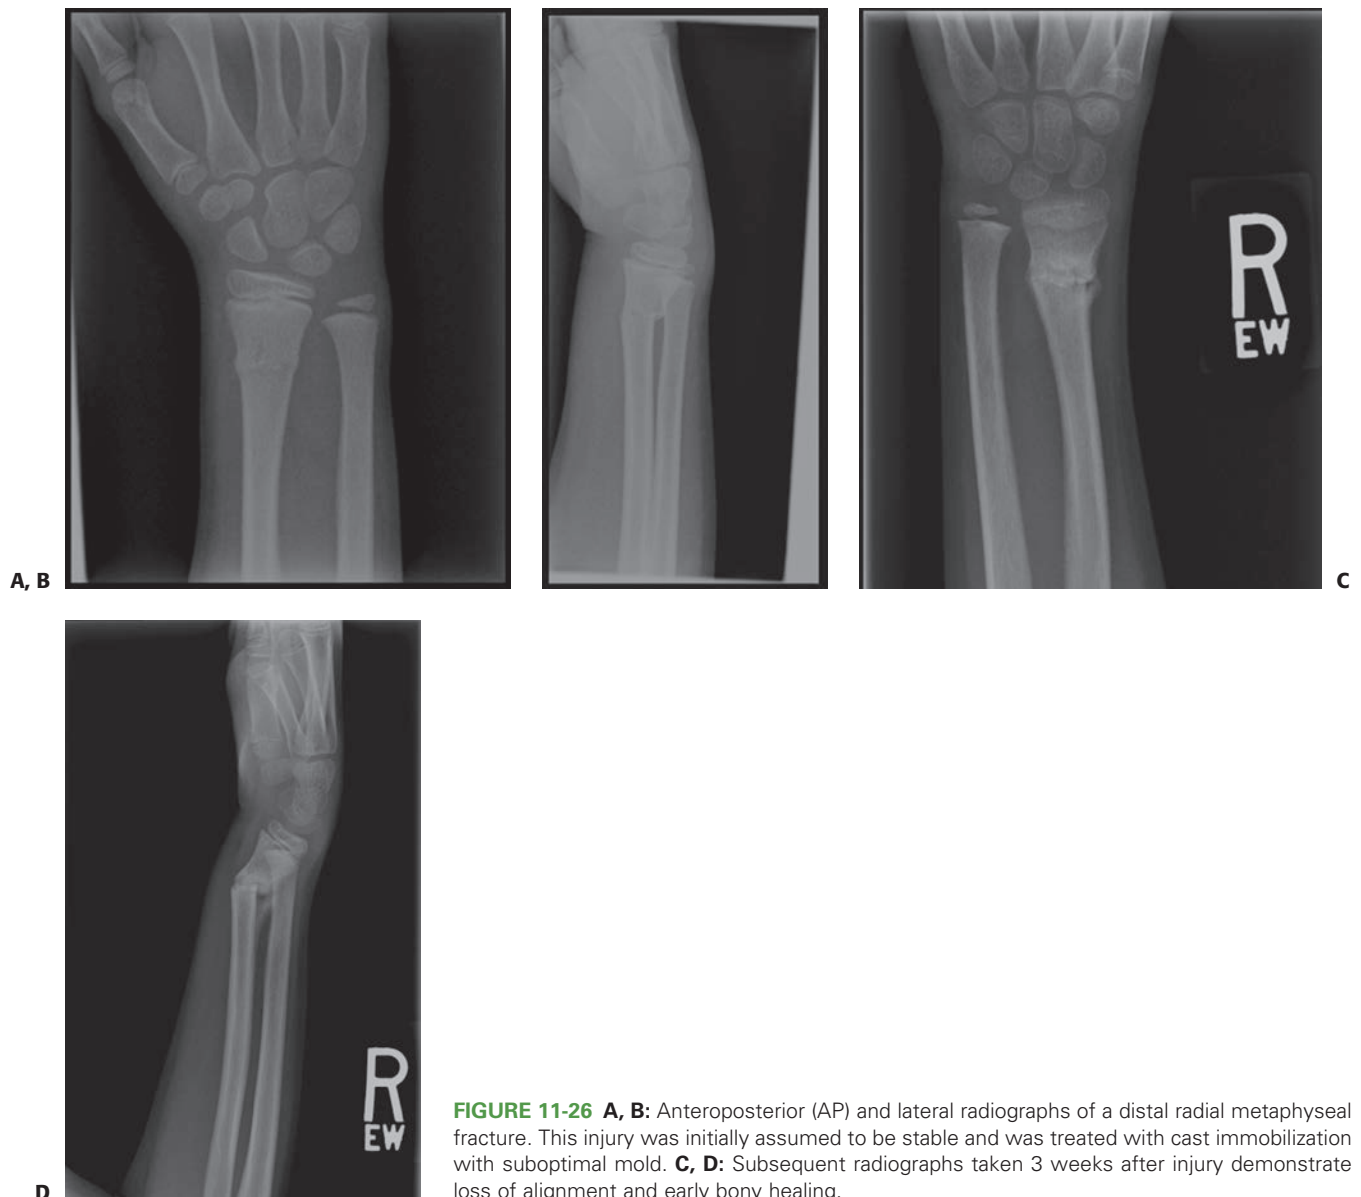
A, B: Anteroposterior (AP) and lateral radiographs of a distal radial metaphyseal fracture. This injury was initially assumed to be stable and was treated with cast immobilization with suboptimal mold. C, D: Subsequent radiographs taken 3 weeks after injury demonstrate loss of alignment and early bony healing.
